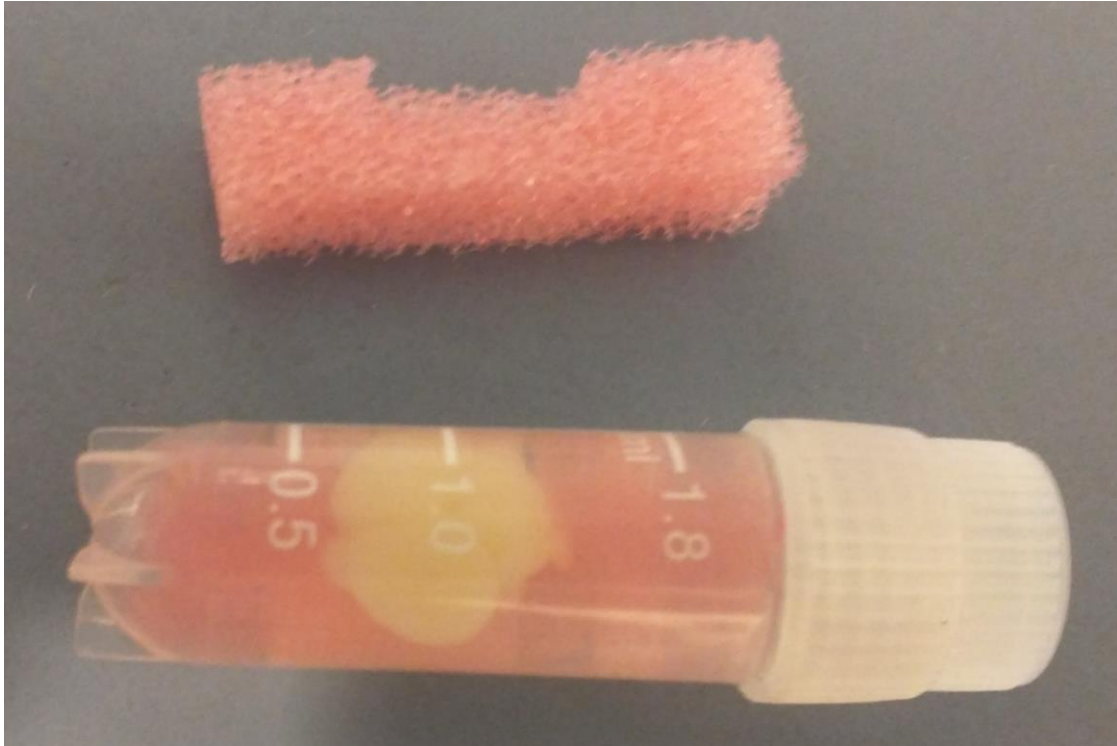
Preparation for MRI scanning. The brain is immersed in Fomblin and held in place with a specially cut piece of sponge.
